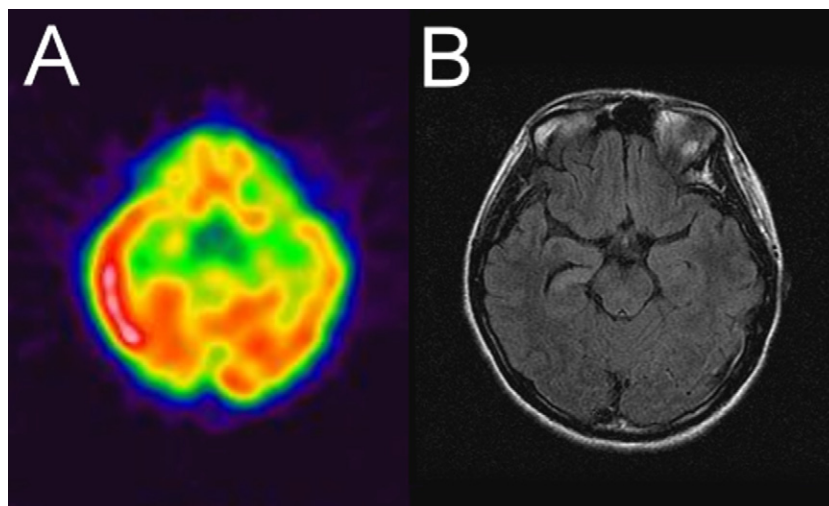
(A) Ictal SPECT revealed regional hyper-perfusion over the right parietal and temporal lobes. (B) Interictal MRI showed hyperintensity on fluid-attenuated inversion recovery-sequences image over the right medial temporal area.
